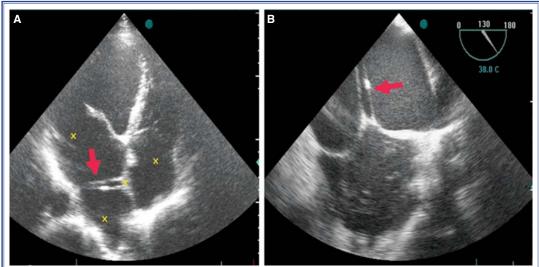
(A) Two fibromuscular membranes, which have a railway appearance and divide the left atrium into three chambers are seen in the apical four chamber view of transthoracic echocardiography. (B) Two fibromuscular membranes with a railway appearance dividing the left atrium into three chambers are seen in transesophageal echocardiographic view.
